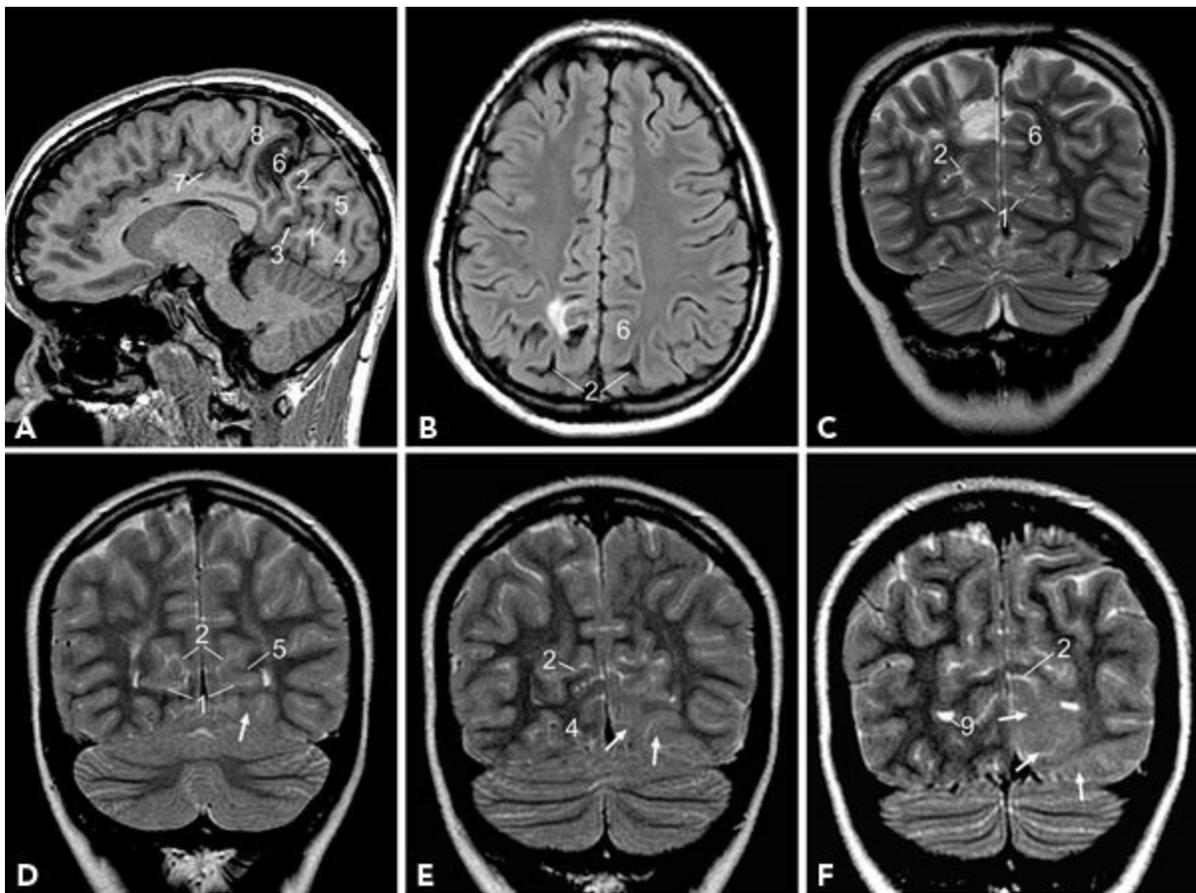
Lesions around the calcarine fissure and parietooccipital sulcus. A–C: Residual tumor with postoperative changes noted in the right precuneus region displayed in sagittal, axial, and coronal planes. Note that the lesion is anterior to the parietooccipital sulcus and posterior to the marginal sulcus. D–F: T2-weighted image shows hyperintensity (arrows) of the cortex and subcortical white matter in the left occipital lobe; lesion is inferior to calcarine fissure in anterior images (D) but involves calcarine fissure, cuneus, and lateral occipital gyrus in posterior sections (F). (1, calcarine fissure; 2, parietooccipital sulcus; 3, anterior calcarine sulcus; 4, lingual gyrus; 5, cuneus; 6, precuneus; 7, cingulate sulcus; 8, marginal sulcus; 9, occipital horn of lateral ventricle.)
